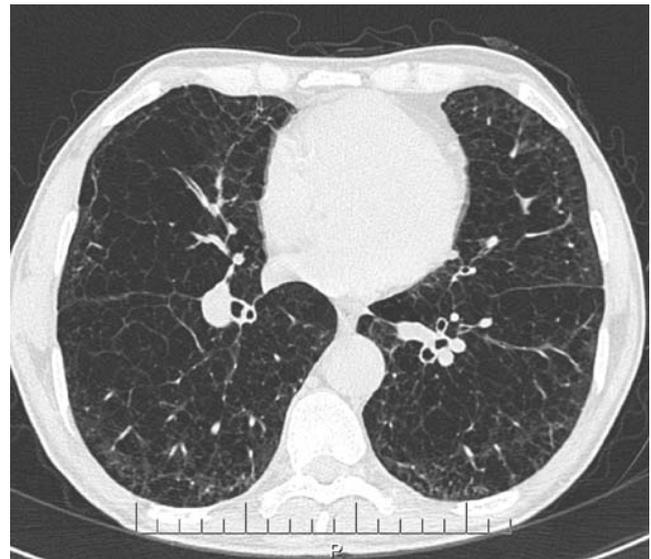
High-resolution computed tomography (HRCT) of a 48-year-old man with a smoking history of 25 pack years. Emphysema is visible.
